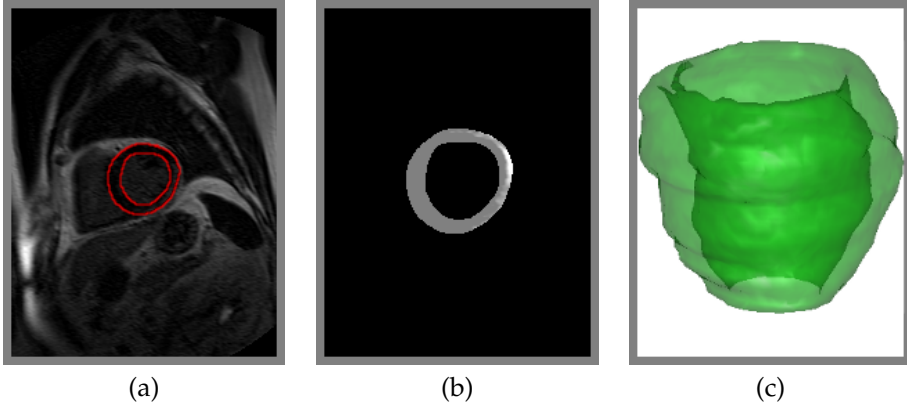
A: Representative slice of LGE MRI data. The left ventricle is shown with red. B: Segmented left ventricle. C: Reconstruction of the left ventricle in 3D.
